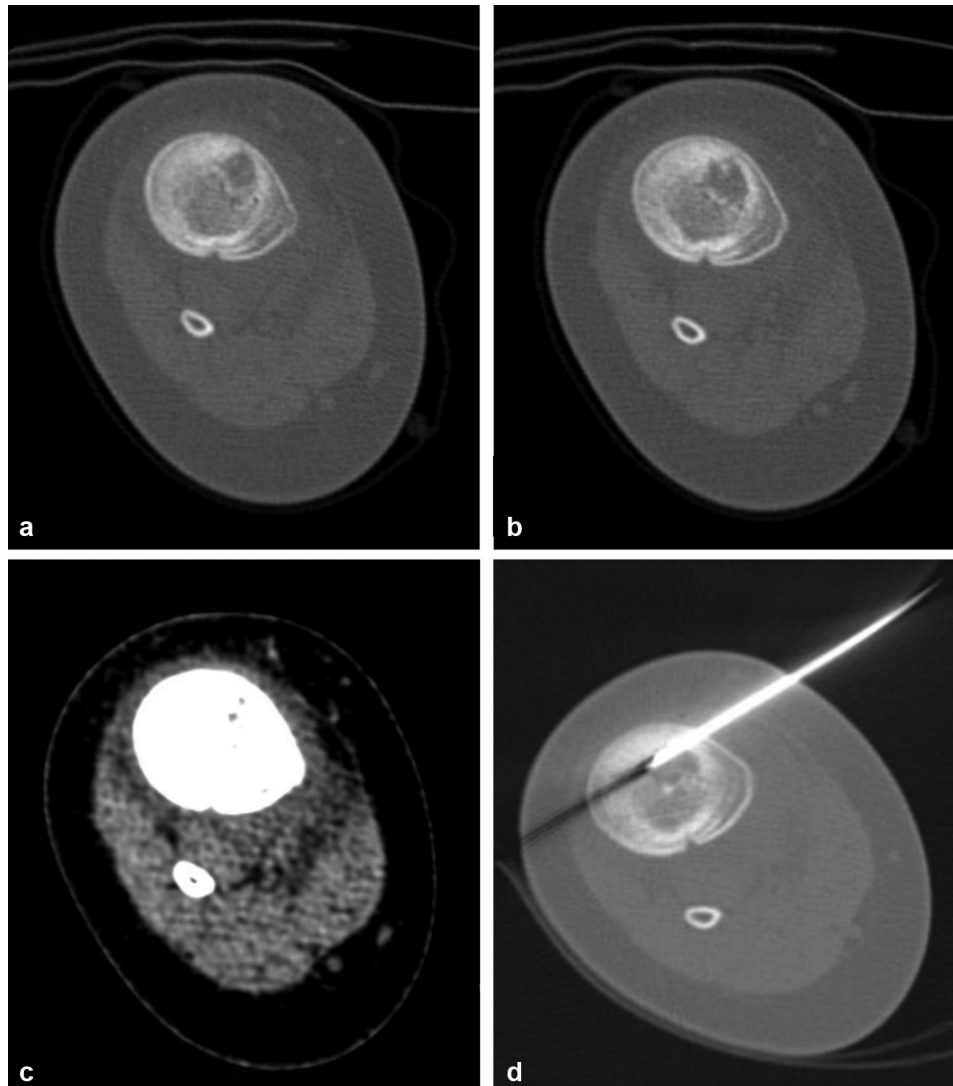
Right tibia osteolytic lesion (a) with calcifications (b) and slight soft tissue heterogeneity (c). Biopsy site determination with surgical wire (d) (a, b, c, d: axial computed tomography).
